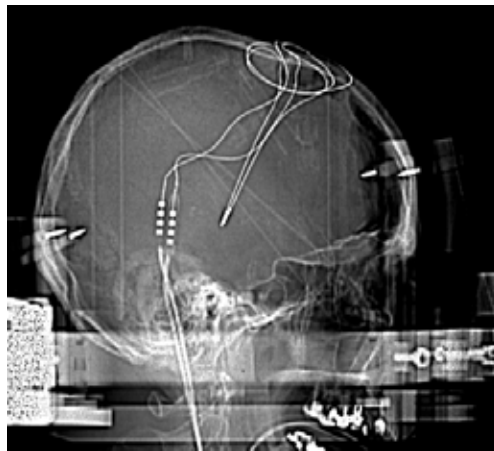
X-ray image showing DBS electrodes bilaterally implanted in the subthalamic nucleus (STN).
